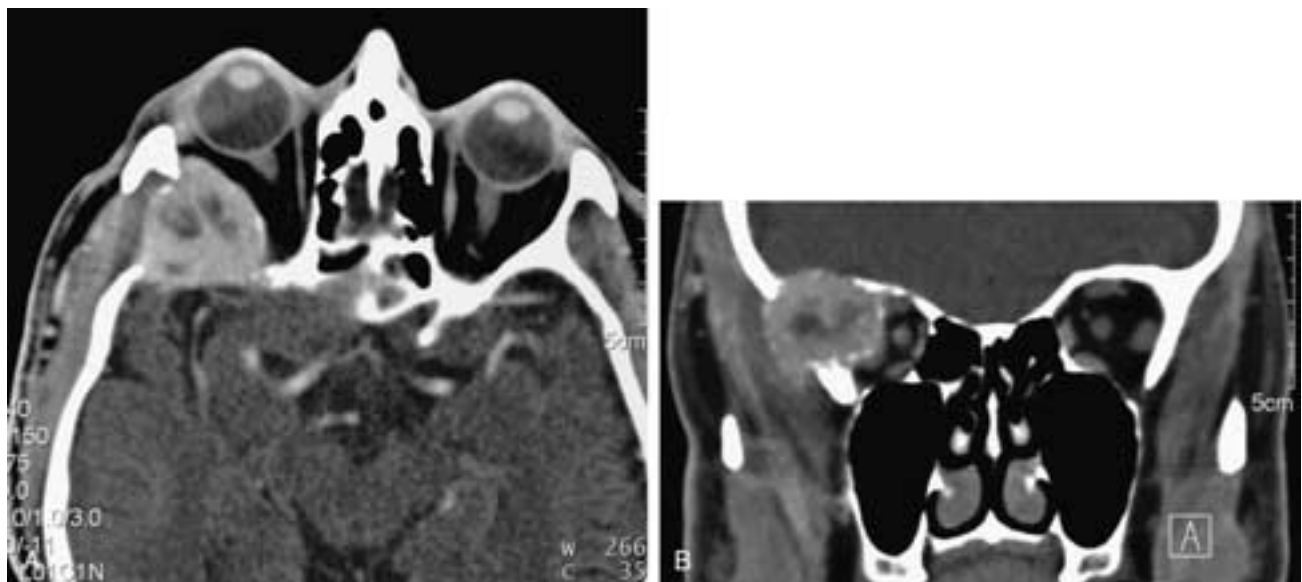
Metastatic renal carcinoma to the sphenoid triangle (greater wing of the sphenoid). A, The tumor is seen replacing the bone of the sphenoid triangle and extending into the orbit, temporalis fossa, and middle cranial fossa. B, Coronal CT postcontrast image.
